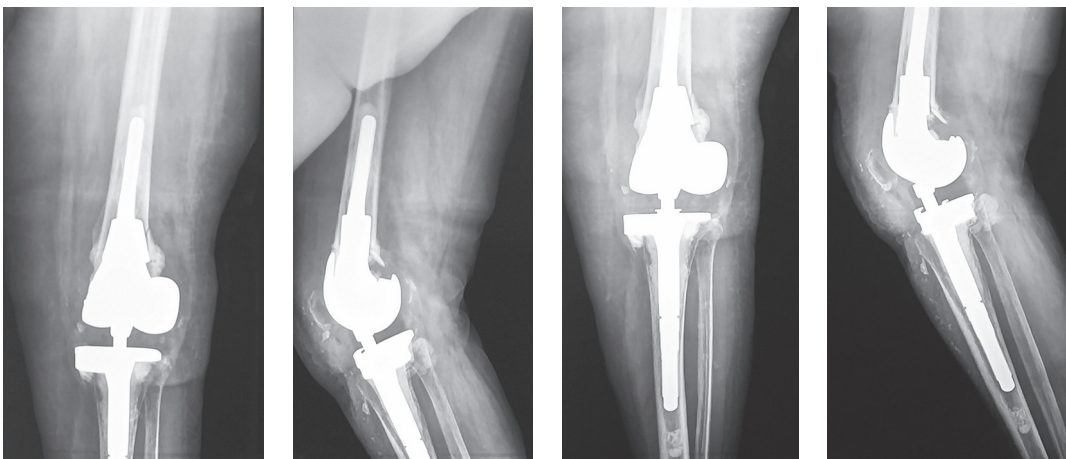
Postoperative X-rays of female patient, 66 y.o. The femoral component was placed with diaphyseal and metaphyseal cones, the position of the components and the level of the articular line are correct.
